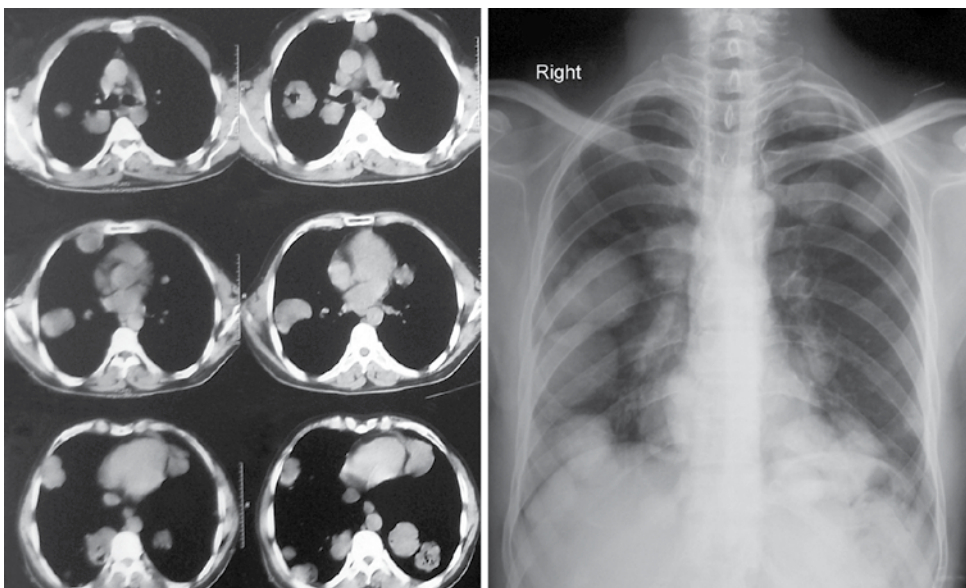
Pulmonary metastasis on X-ray chest and CT chest
